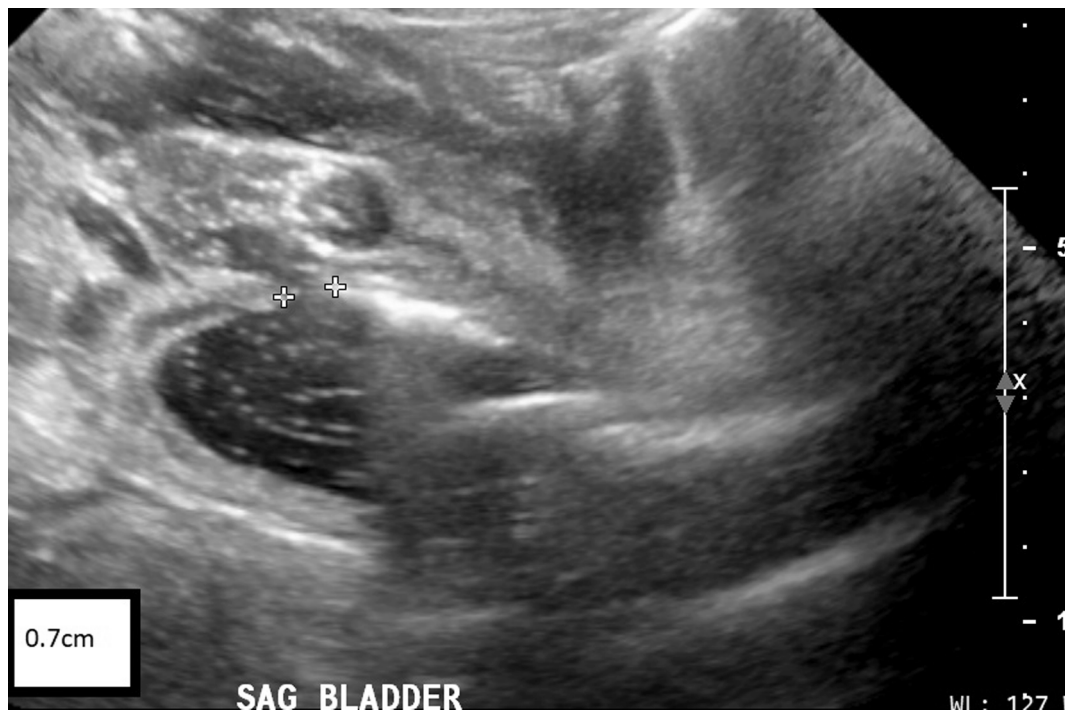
Ultrasound with bladder rupture. Ultrasound with anterior initial extraperitoneal leak. Diameter of rupture marked with calipers, 0.7 cm.
